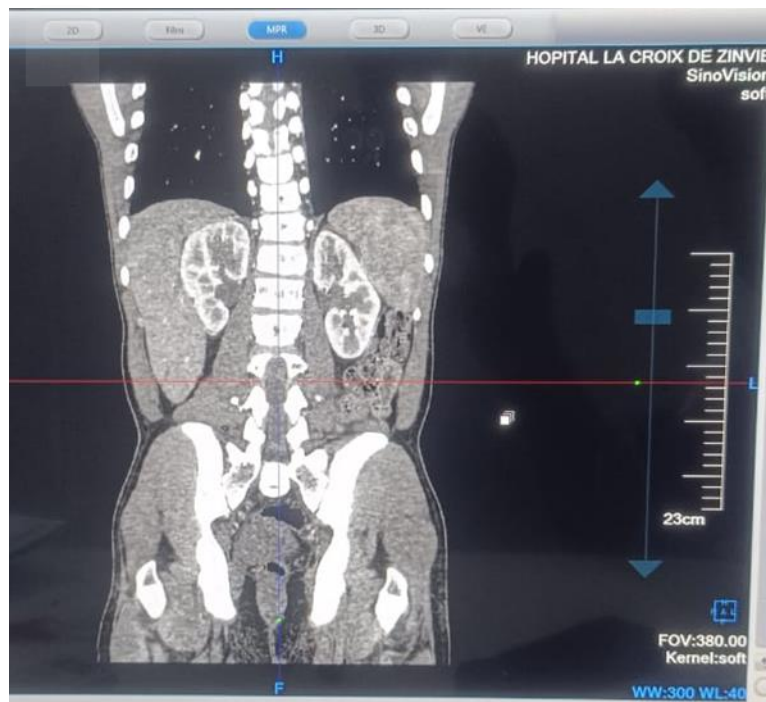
Bilateral hydronephrosis on Uro-CT
